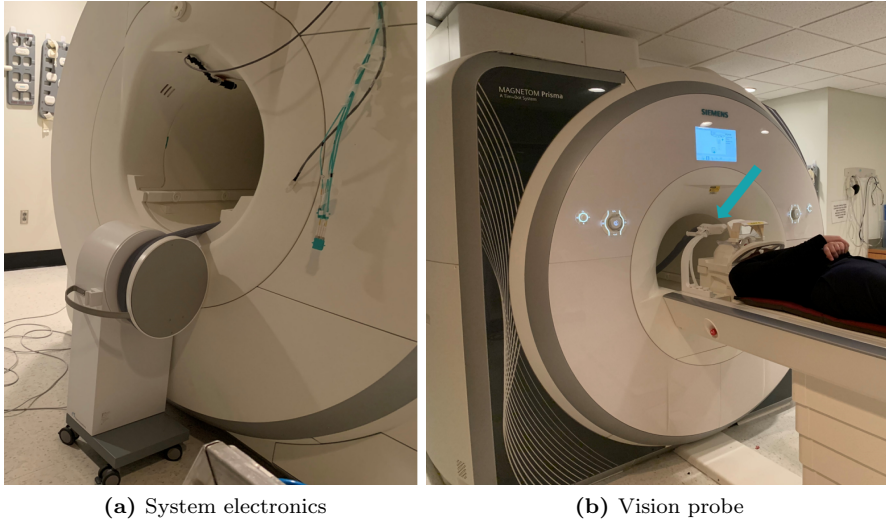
The setup of the TCL system on the Siemens MAGNETOM Prisma MRI scanner used in *study III*. The arrow indicates the TCL system’s optics (vision probe). The vision probe is mounted to the scanner table to have sufficient visibility of the patient’s face through the openings in the head coil.
